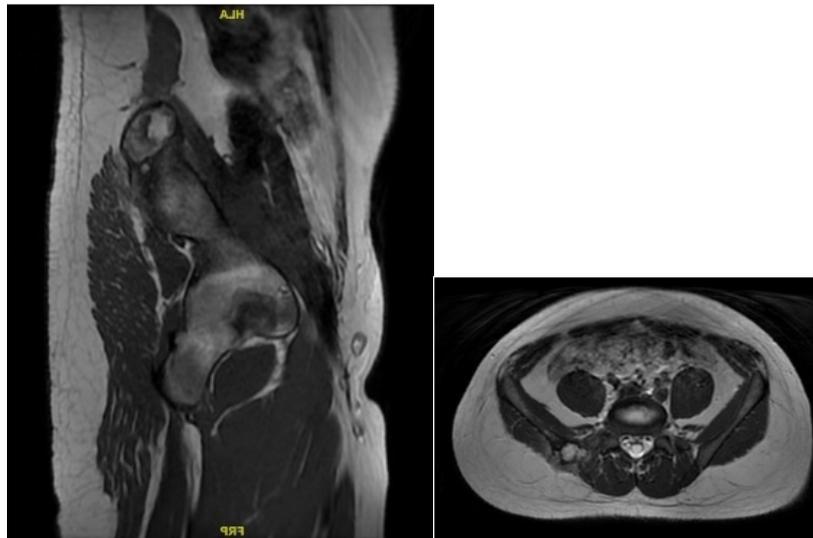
MRI pelvis with contrast demonstrated iso-hyperintense lesion on T1WI-T2WI with hemorrhagic component and lobulated margin at right superoposterior iliac wing. A: Sagittal view; B: Axial view.
